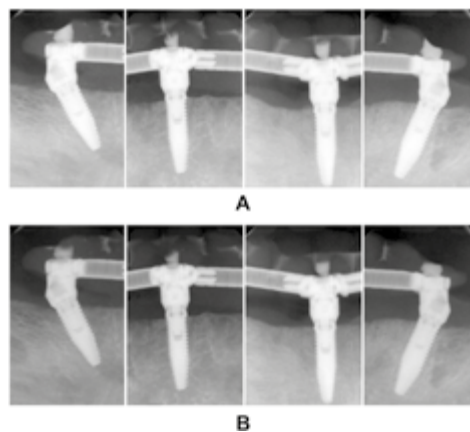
(A) Intraoral radiographs after implant surgery and immediate loading. (B) After 24 months, stable marginal bone levels were shown.
